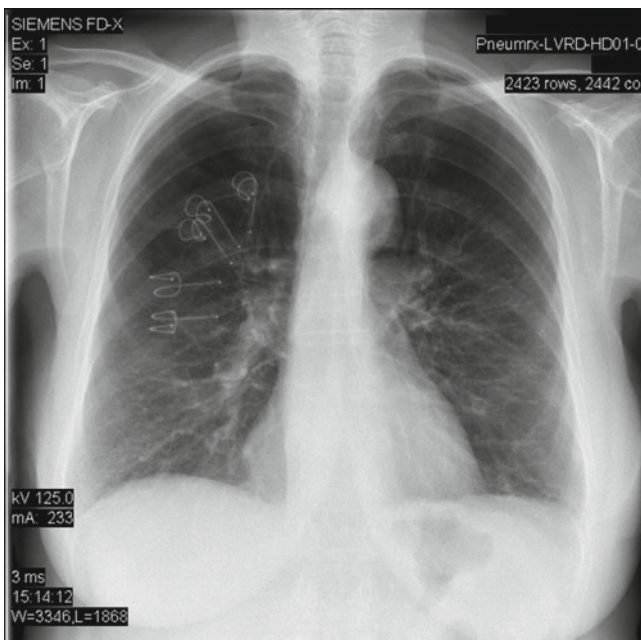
Chest X-ray of a patient who underwent placement of multiple implants for severe upper lobe predominant emphysema
